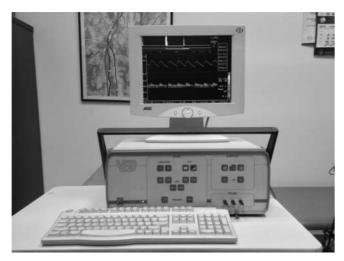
VED (Vascular Echo Doppler) measurement kit
